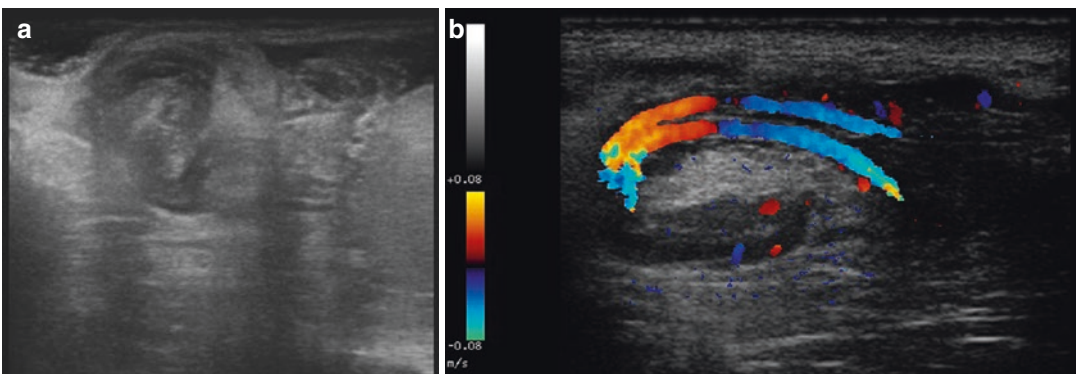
(a) At the US scrotal analysis of the twisted testis, the spermatic cord presents a spiral aspect also known as ‘whirlpool sign’. (b) At colour Doppler ultrasound, flow can be detected in the vessels of the ‘whirlpool mass’
